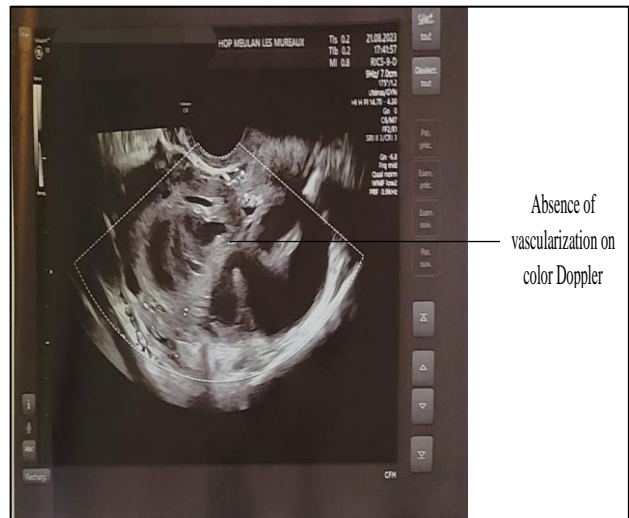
Color Doppler ultrasound of pelvic masses.
